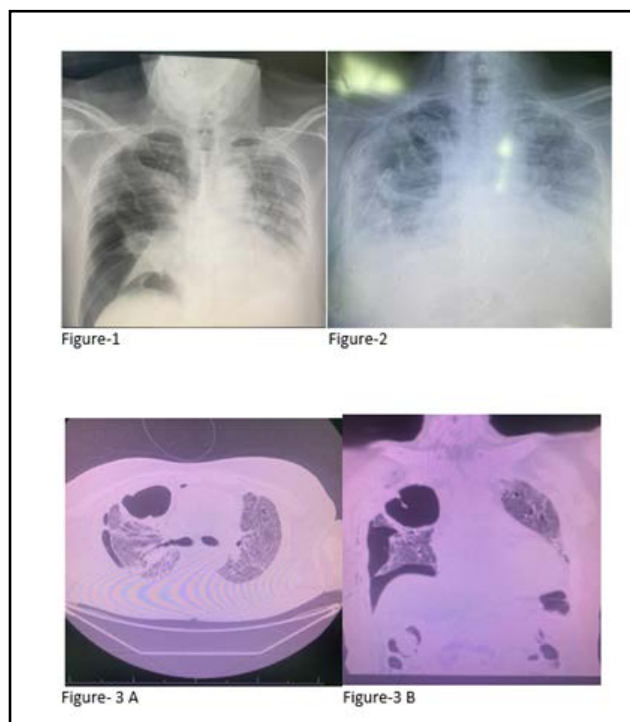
Chest X-ray showed a large pneumothorax in the right side.
